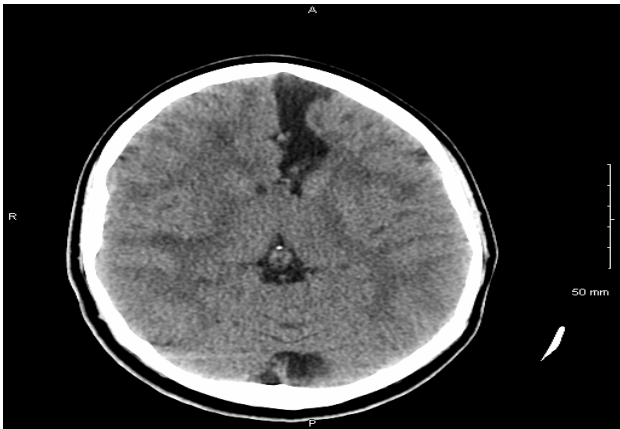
CT head without contrast showing confluent white matter hypodensities of uncertain chronicity.
